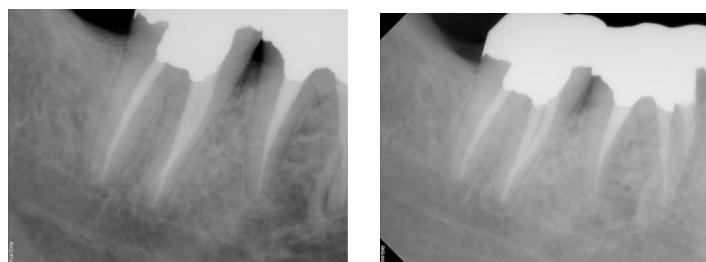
Periapical (PA) radiographs of teeth #30 and 31.
